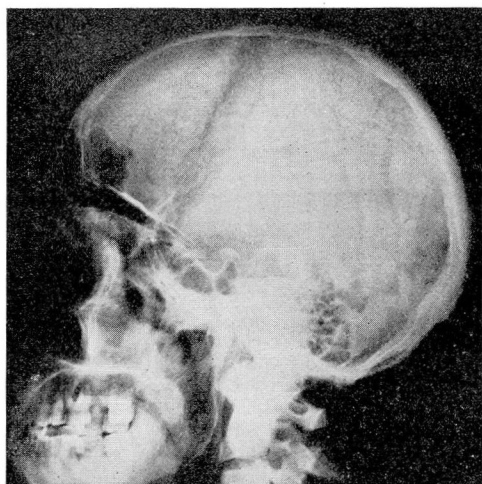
Roentgenogram of the skull. Extensive changes in the cervical region of the spine mandible, maxilla, and bones of the base of the skull.
